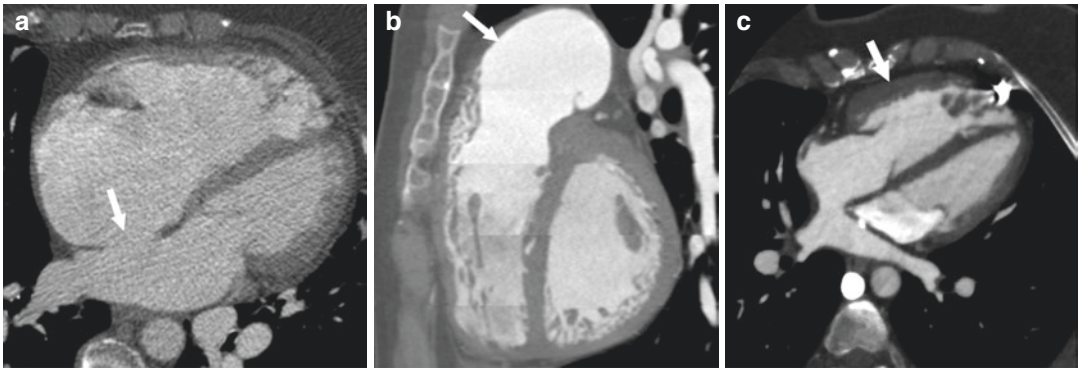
Congenital heart disease. (a) 4-chamber contrast-enhanced CT image shows a large ostium secundum type of atrial septal defect (arrow), resulting in right atrial and ventricular dilation. (b) Short axis contrast enhanced CTA in a patient with repaired Tetralogy of Fallot shows aneurysmal dilation of the right ventricular
